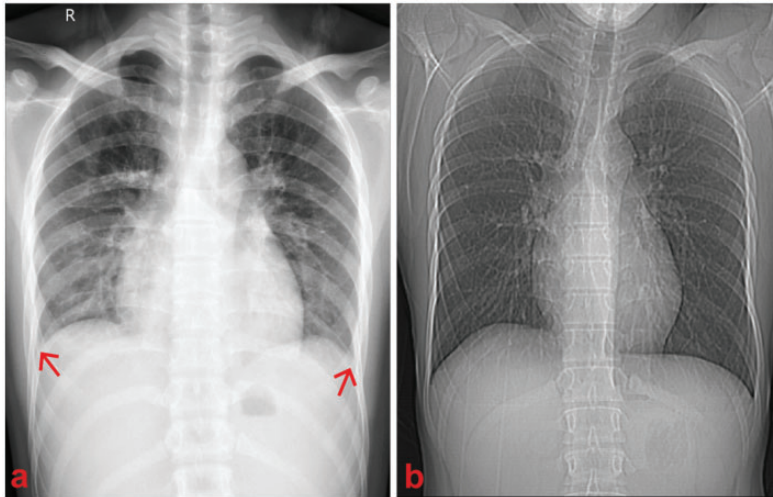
Radiographic findings. (a) Chest X-ray revealed an enlarged heart shadow with small amounts of bilateral pleural effusion (red arrow) on admission and (b) Chest computed tomography revealed a normal heart shadow after 1 month.
